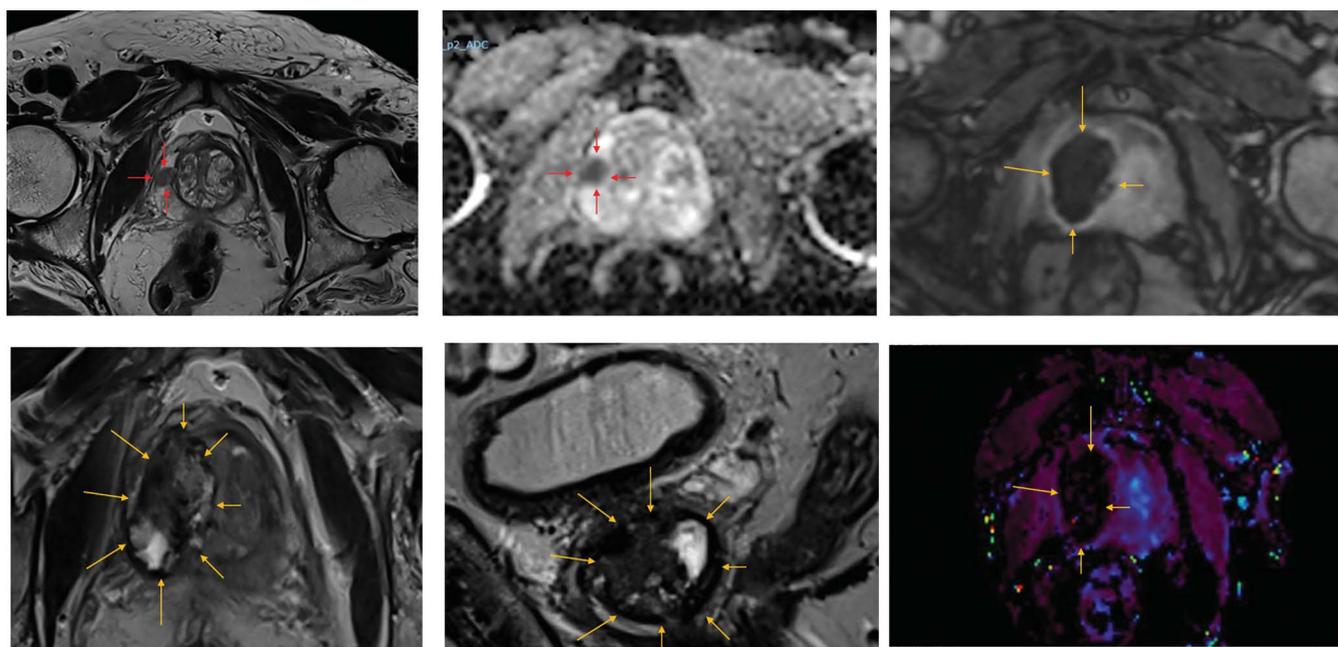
Example of standard treatment control. Tumor located in right peripheral zone treated with a safety margin >10 mm confirmed by a multiparametric MRI 3-5 weeks after the procedure. Arrows delineate both tumor and treated volume.
